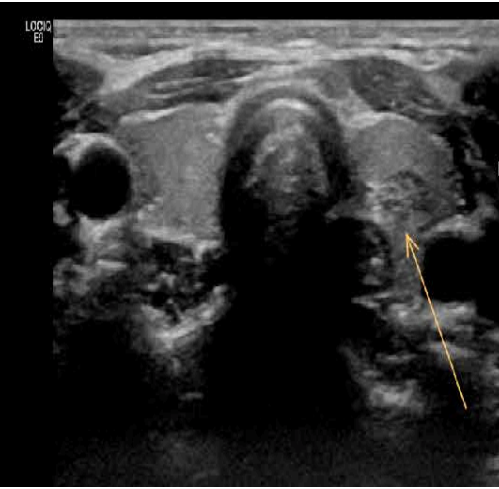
(Patient2): Thyroid ultrasound showed a solitary, well-defined hypoechoic nodule measuring 6×4 mm located at the posterior aspect of the left lobe, with central mixed echogenicity.
